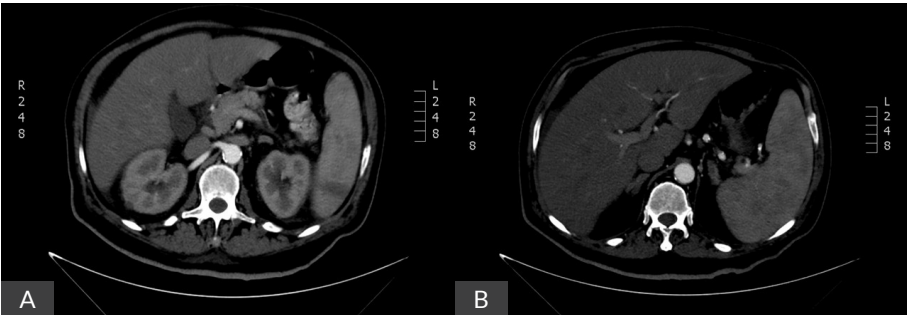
Abdominal computed tomography (CT) scans performed during the patient's hospitalization: A) Initial abdominal CT scan showing an ischemic infarct in the lower pole of the spleen; B) CT scan after clinical deterioration revealing hypo vascular splenic lesions suggestive of micro abscess.
